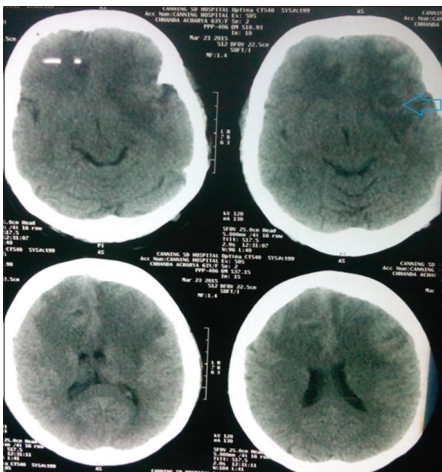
Computed tomography scan brain shows large hypodense areas in both frontal lobes, suggestive of extensive edema
